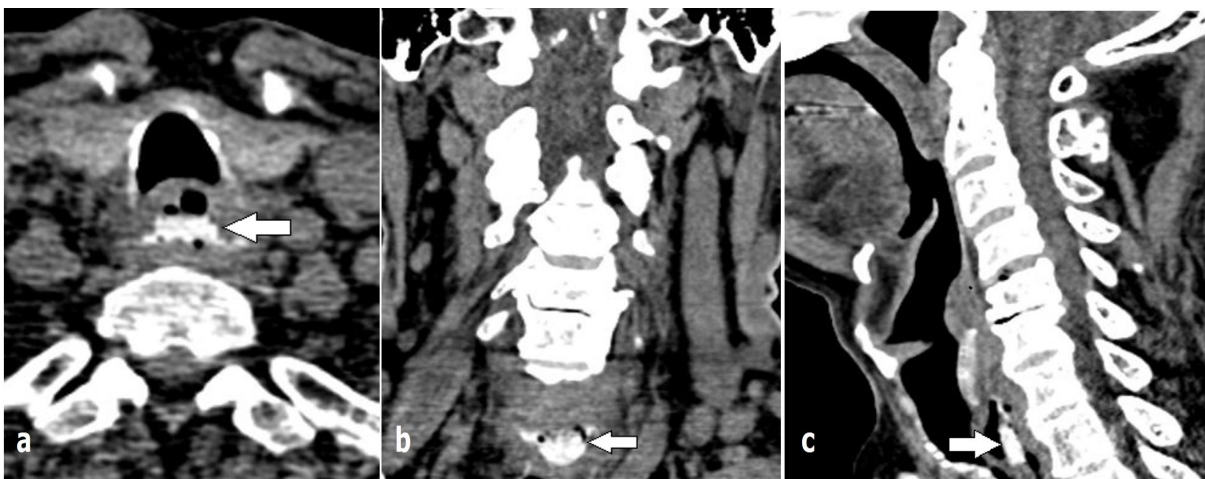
CT images showing the impacted FB (white solid arrow) at mid esophagus. a) axial plane, b) coronal section, c) sagittal section.
